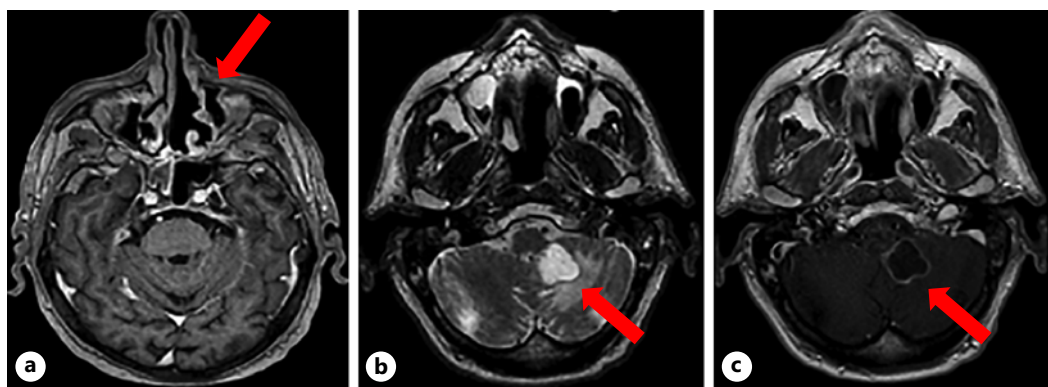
a CT scan (axial view) shows response of the nasopharyngeal lesion. b CT scan (axial view) shows appearance of a left cerebellar tonsil lesion.
